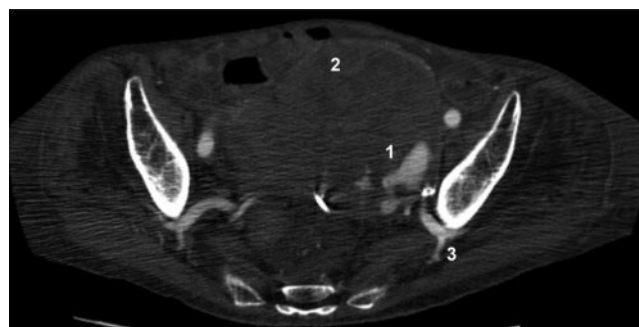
CT angiogram showing rupture of the left internal iliac artery aneurysms with (1) contrast filling the sac, (2) a large pelvic haematoma and (3) a Type II endoleak via the superior gluteal artery.
